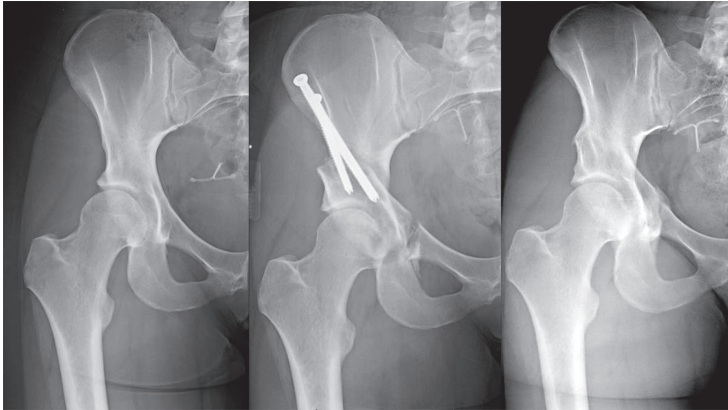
Left:* X-ray of a dysplastic hip, showing insufficient coverage. *Middle:* Post-operative X-ray of a triple innominate osteotomy. The area around the acetabulum has been osteotomized in three locations, allowing its rotation in the coronal plane, and improving the coverage over the femoral head. *Right:* X-ray of a successful triple osteotomy. The acetabulum provides enough coverage to relieve pain and this allows the patient to return to daily activities.
